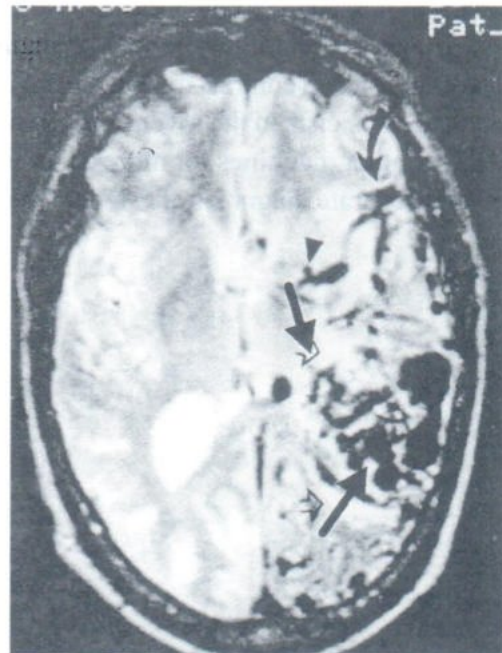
CE.CT. showed AVM which replaced normal brain causing nervous deficit to the patient.
